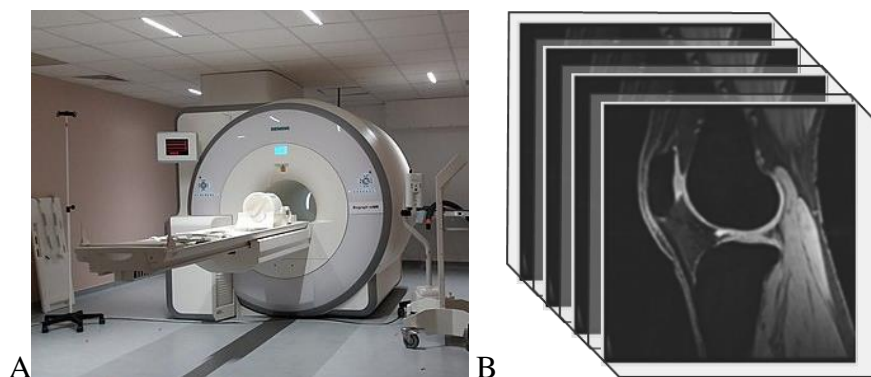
A. MR scanner & B. sample volumetric MR image (note slice thickness). Adapted from Wikimedia Commons¹⁵⁷ and with permission from Jordan et al. 2014¹⁵⁸.
